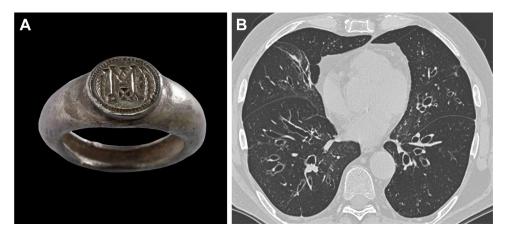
A, Image of a signet ring. (Image courtesy Wikimedia Commons.) B, Note classic signet ring sign on axial CT images in a patient with cystic fibrosis. Also note the tram-track sign.
